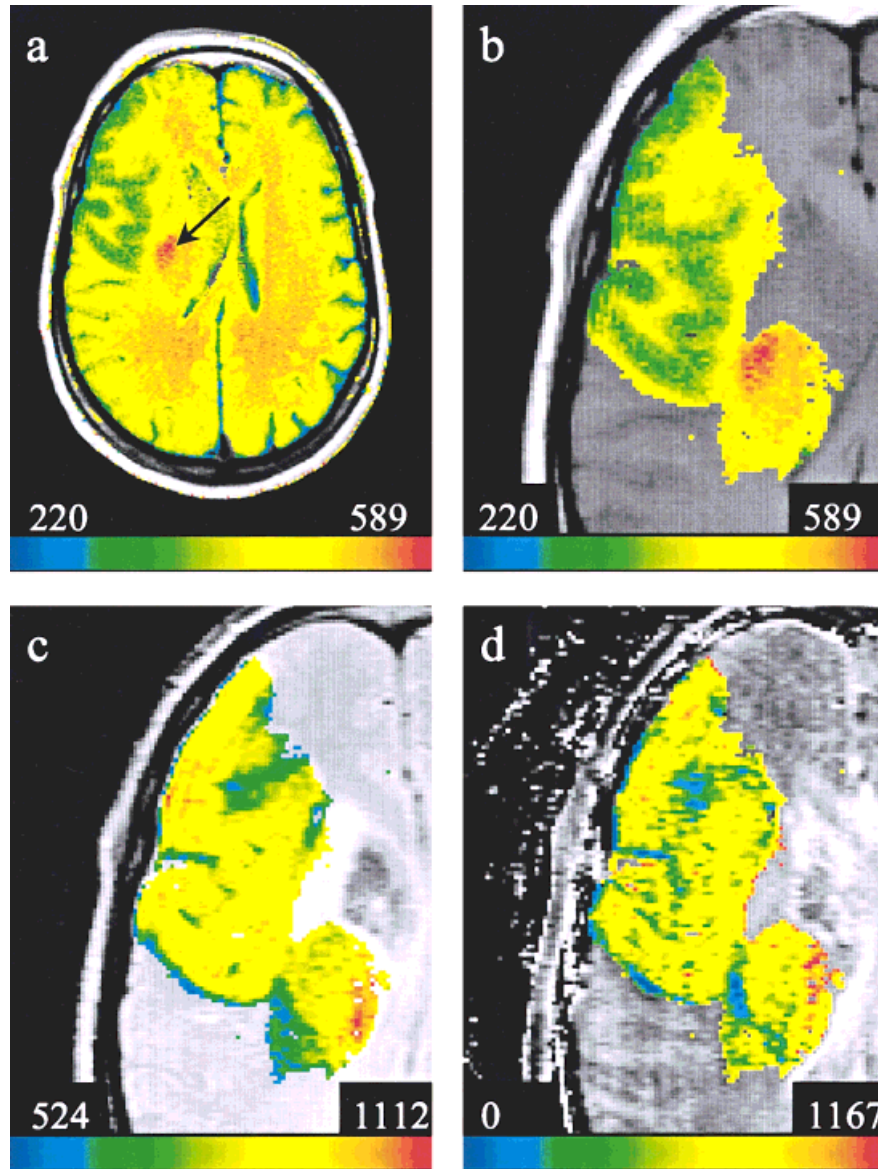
Representative results of an interactive 4D histogram-based analysis of the data presented in Fig. 3 using the T_1 w image (3a), the T_2 w image (3b), the DWI (3c), as well as the ADC map (3d). The values of image parameters are color-encoded according to their segmentation ranges (shown in the lower bar; arbitrary units [a.u.] for signal intensities [SI] and $\mu\text{m}^2/\text{sec}$ for ADC). Here both the color-encoded overlays and the original parameter images are displayed. a: T_1 w SI for unaffected and ischemic brain tissues (not shown are the overlays of T_2 w SI [segmentation range 291–1124 a.u.], of the diffusion-weighted signals [s.r. 42–849 a.u.] and of the ADC values [s.r. 0–3493 $\mu\text{m}^2/\text{sec}$]). The color-encoded T_1 w SI allow the differentiation of GM, WM, a lateral part of the ischemic region with reduced T_1 w SI indicating edema, and a hyperintense hemorrhagic region within the medial part of the ischemic region (arrow). b–d: The segmentation of tissue that is hyperintense in the DWI (compare Fig. 3c) is achieved by changing the segmentation ranges. Original and color-encoded overlays of the magnified segmented parts of T_1 w SI (b), T_2 w SI (c), and ADC values (d) visualize in more detail the spatial heterogeneity of the parameters. In contrast to the frontomedial region with T_2 signal loss (compare Fig. 3b and c) the hemorrhagic region (a, arrow) in the medial part of the segmented ischemic region still has T_2 w and diffusion-weighted SI well above noise level, leading to more reliable ADC values. Within the segmented overlay (d) local values of the ADC range from subnormal (blue and green) to above normal values (red). The mean ADC value of the segmented region is 60% that of mean ADC value of unaffected brain parenchyma. (Not shown is the overlay of diffusion-weighted SI with a segmentation range of 461–788 a.u.)
